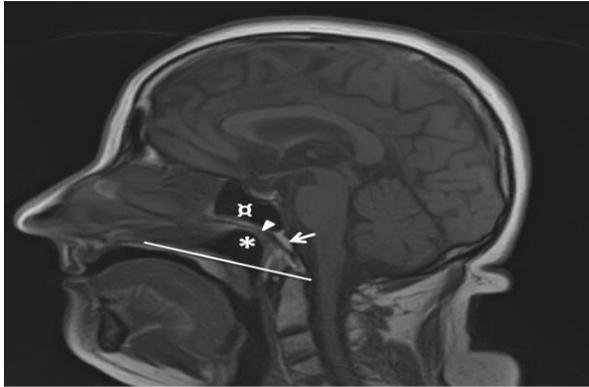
Sagittal T1- weighted MRI image showing the normal nasopharynx (asterix) and its superior limit represented by basiphenoid (arrowhead) and clivus (arrow). Superiorly is sphenoid body with a large sphenoid sinus. Inferiorly, the junction between nasopharynx and oropharynx (white line) is represented by a line between the hard palate and anterior arch of C1 vertebra (Turliuc *et al.*,2016c).
